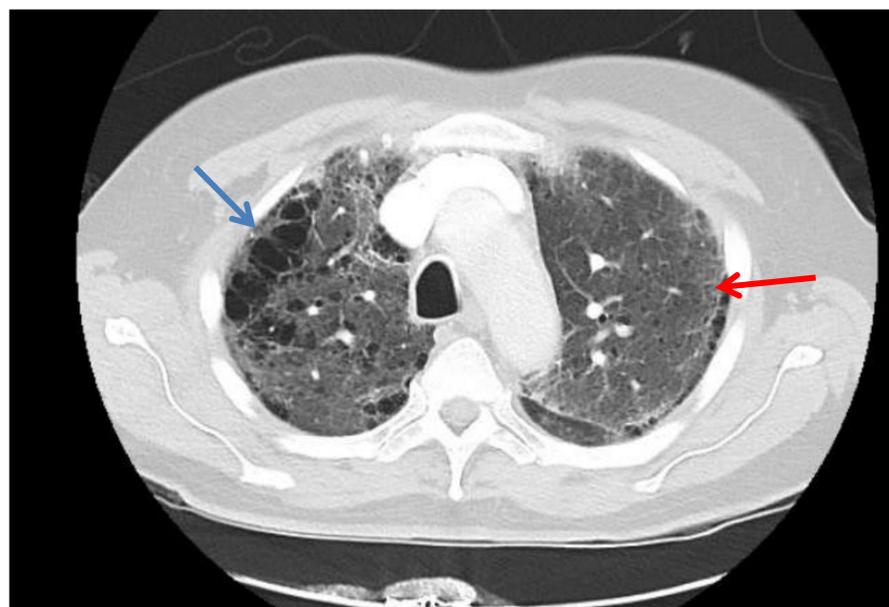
CT scan of lungs showing bilateral ground glass opacities (red arrow) and blebs (blue arrow).
